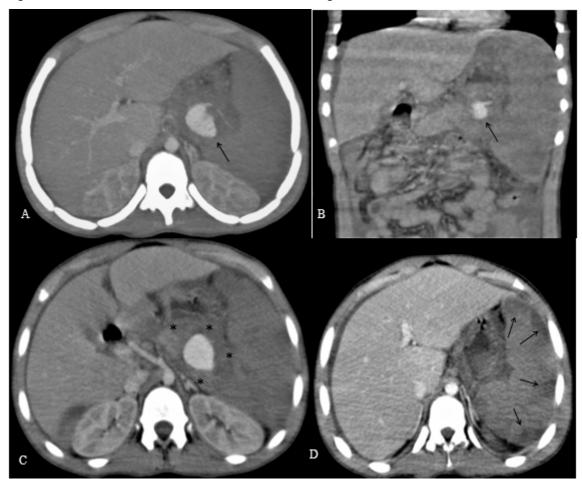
Axial(A) and coronal(B)) contrast-enhanced CT images
